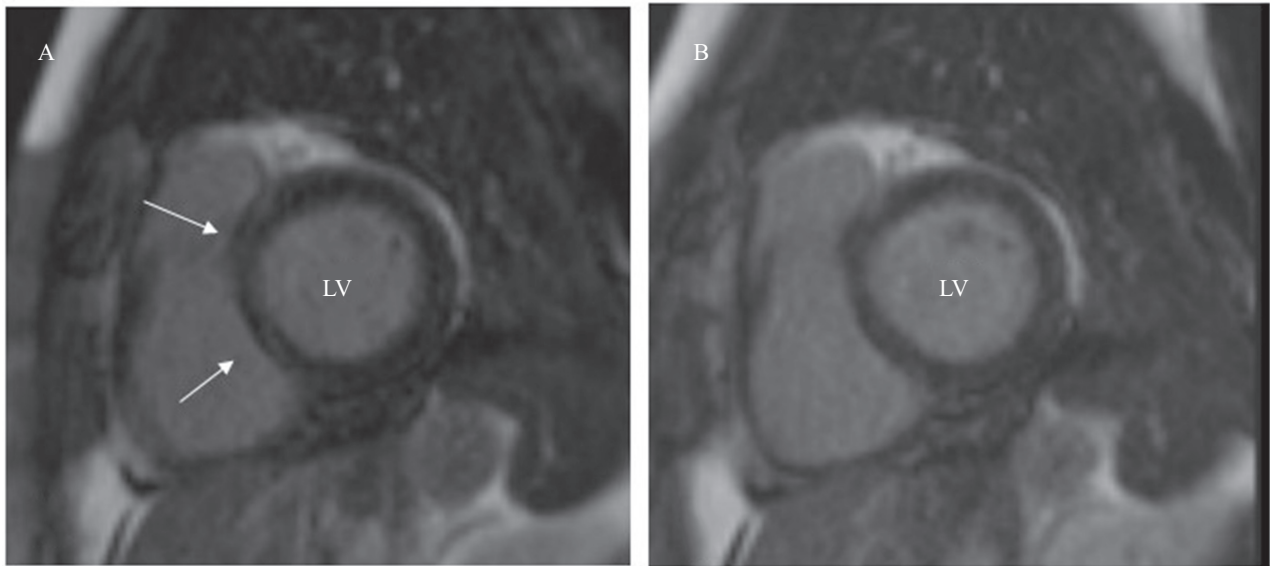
Cardiac magnetic resonance images of a 57-year-old patient with early RA. (A) Short-axis view of the heart showing linear late gadolinium enhancement (LGE) of the basal interventricular septum, segments 2–3 (arrows), at baseline imaging. (B) At follow-up imaging, LGE had cleared. LV, left ventricle.
